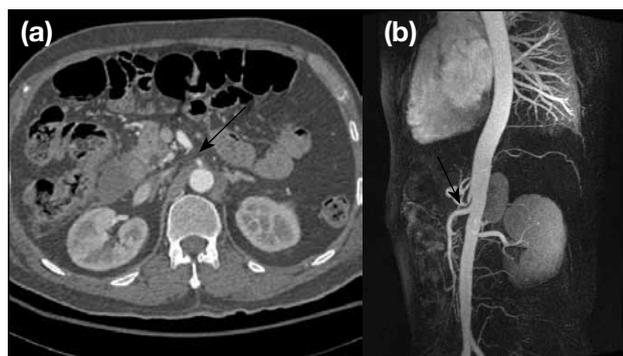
Patient A: (a) Narrowing of celiac artery (arrow) in a computed tomographic scan with curve reformation appearing along the celiac trunk. (b) Typical hook-like appearance of the celiac artery (arrow) revealed by magnetic resonance angiography.
